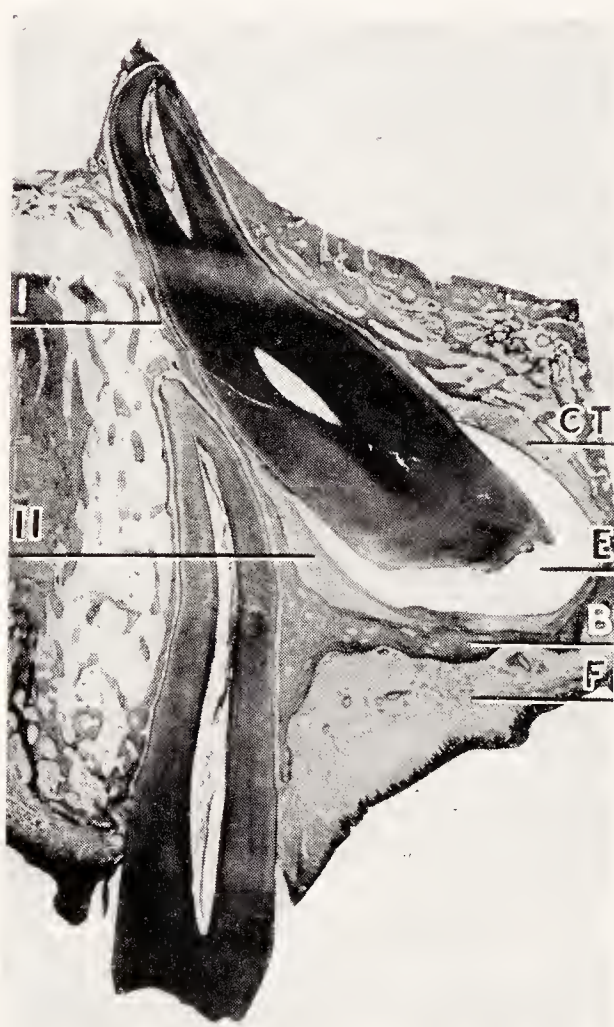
Mesio-distal section through an embedded upper cuspid and an erupted first bicuspid. *E*, enamel of embedded cuspid; *CT*, connective tissue capsule surrounding the crown of the cuspid; *B*, bone covering the cuspid; *F*, fibrous tissue of the edentulous ridge overlying the cuspid. Higher magnifications of areas *I* and *II* are shown in Figures 368 and 369. (Gottlieb, *Fortschr. d. Zhk.*, courtesy of Georg Thieme, Leipzig.)
